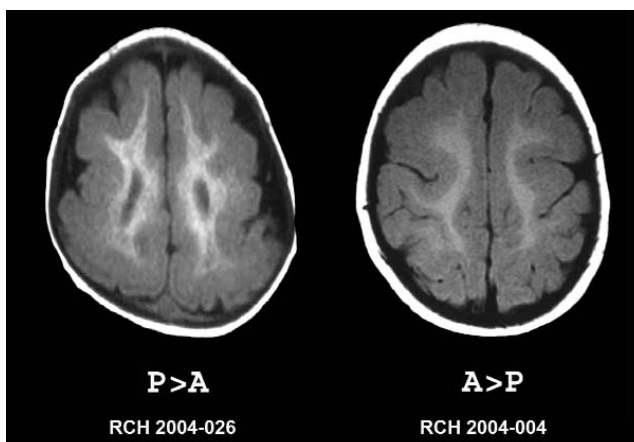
Imaging features of classical lissencephaly contrasting the P>A gradient with the A>P gradient. Axial T1-weighted MRI scans. The image on the left shows near-complete agyria posteriorly transitioning to pachygyria anteriorly. This is the P>A gradient consistent with a mutation of the *LIS1* gene. The image on the right shows severe pachygyria anteriorly transitioning to mild pachygyria posteriorly. This is the A>P gradient consistent with a mutation of the *DCX* gene. MRI, magnetic resonance imaging
